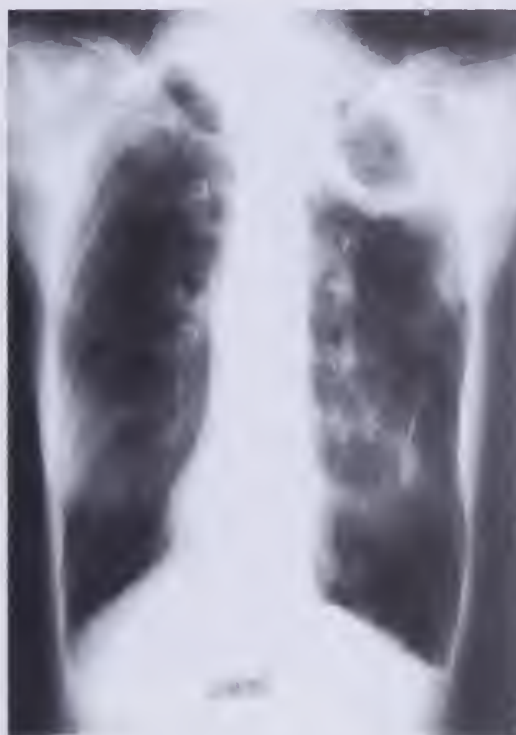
A plain chest roentgenogram showing a large cavitary lesion in the left upper lobe of a patient with severe underlying chronic obstructive pulmonary disease and numerous positive sputum cultures for MAC.
